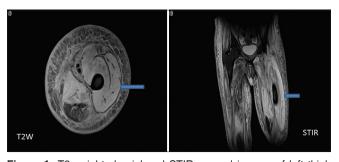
T2-weighted axial and STIR coronal images of left thigh show bulky and diffusely hyperintense vastus muscles with large areas of nonvisualized muscle fibers – suggestive of myonecrosis (arrow)
